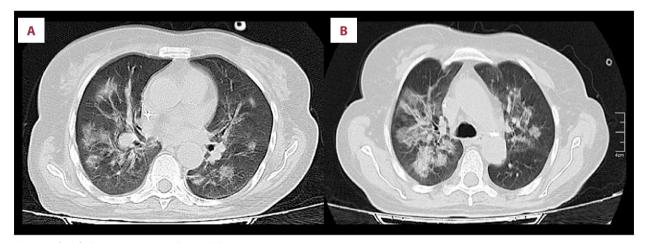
(A, B) Thoracic CT. Bilateral consolidative images.
